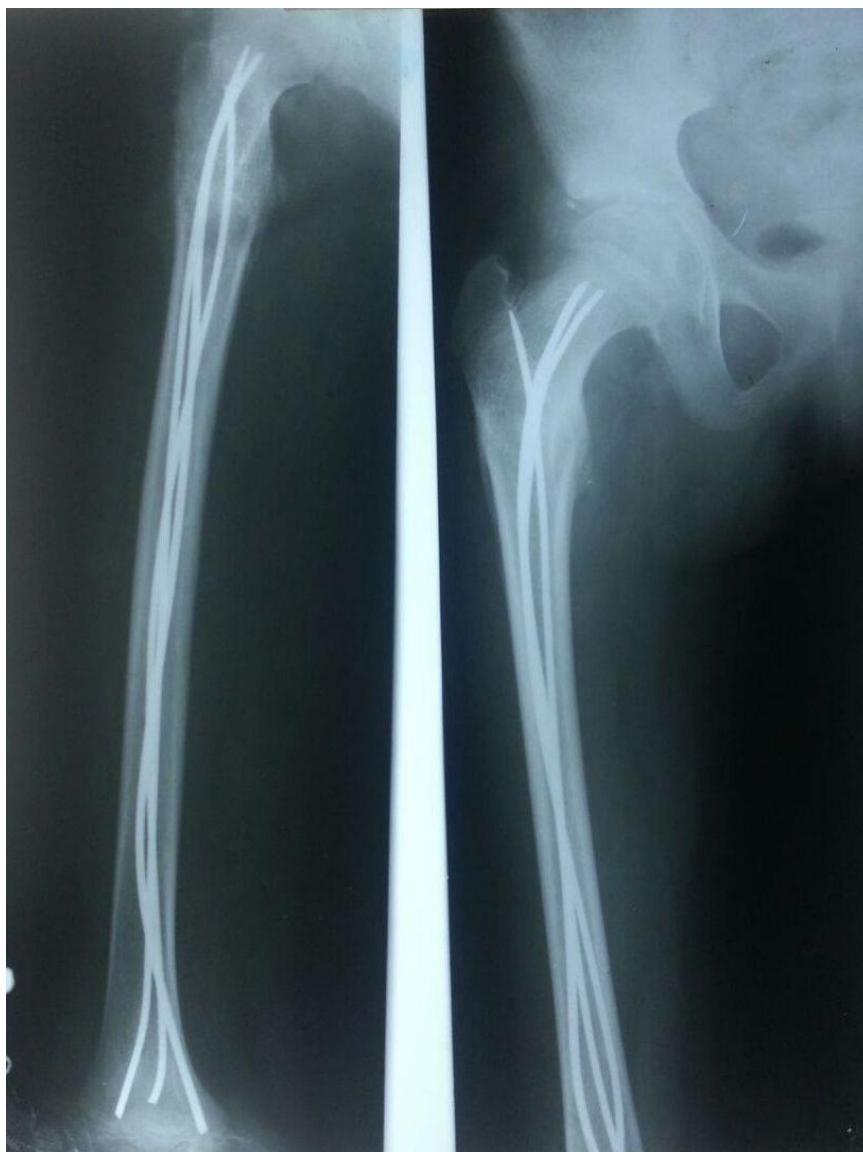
Follow-up x-ray at 1 year of right hip with thigh showing good union
